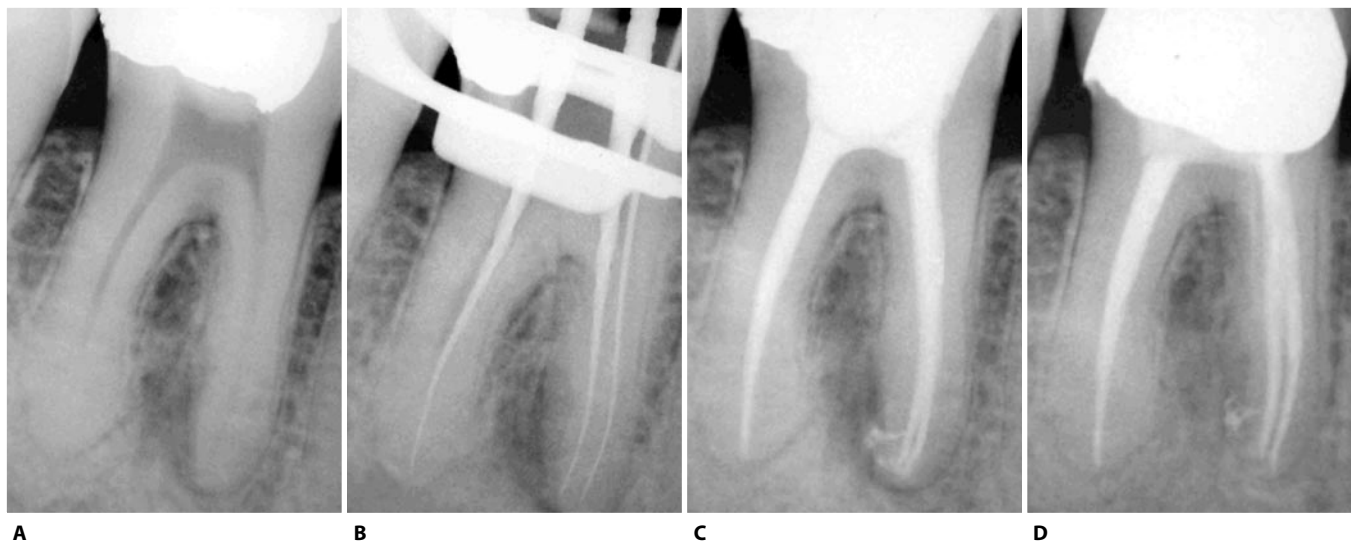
A. Endodontic treatment of a lower right first molar with a necrotic pulp and a substantial periapical lesion associated with the mesial root. B. Working length radiograph. C. One should note the presence of a large lateral canal in the mesial root which opens directly in the periradicular lesion. D. The 15 month recall reveals good bone healing.
